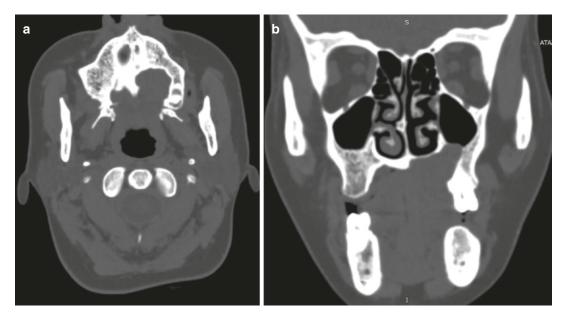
Adenoid cystic carcinoma. (a) Axial CT slice reveals a well-defined hypodense lesion at maxillary left premolar site and hard palate. (b) Coronal CT slice reveals
